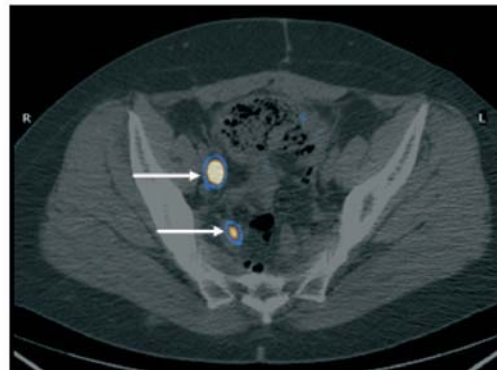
A 40-year-old woman was diagnosed with ovarian cancer 20 months earlier and was treated with radical surgery including hysterectomy, bilateral salpingo-oophorectomy, and anterior resection with end-colostomy. Postoperatively she had a right pelvic abscess that had resolved. She was found on routine follow-up to have a rising CA-125 tumor marker. Magnetic resonance imaging (MRI) was stable without evidence of recurrence. The transaxial images of CT (*top left*), PET (*top right*), and PET/CT fusion image (*lower*) showed FDG-avid lesions in the pelvis that were proven to be recurrent disease.
